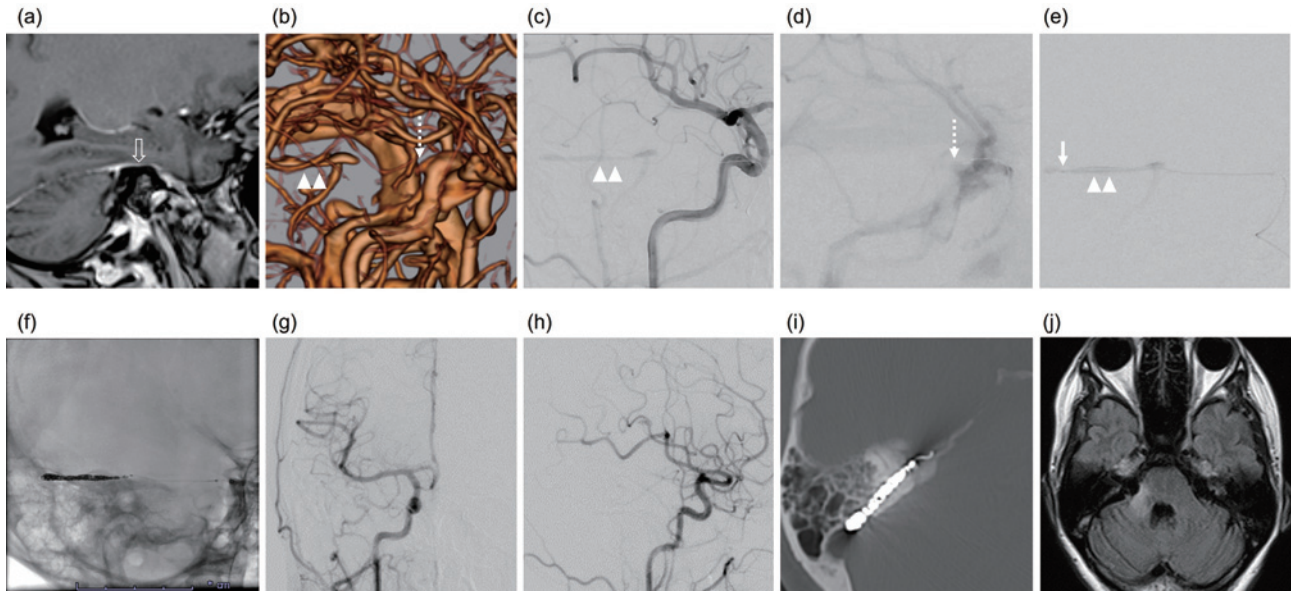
Contrast-enhanced magnetic resonance image (a) showing the anterior segment of SPS was enhanced (open arrow). It meant that the vessel structure presented the anterior part of SPS. Contrast-enhanced computed tomography (b) and right common carotid angiography at arterial (c) and venous phase (d) showing the beak-filling pattern (dotted arrow) of cavernous sinus posterolaterally, and it would connect to the isolated superior petrosal sinus (arrowhead). Microcatheter angiography (e) showing the shunt flow. The arrow indicated the microcatheter tip. Craniogram (f) showing coils in the isolated superior petrosal sinus. Anteroposterior (g) and lateral (h) views after treatment demonstrating no arteriovenous shunt. Postembolization axial computed tomography (i) showing coils in the superior petrosal sinus. All views (b-f) are from the same angle. Magnetic resonance image after 6 months (j) showing an improved venous congestion.
